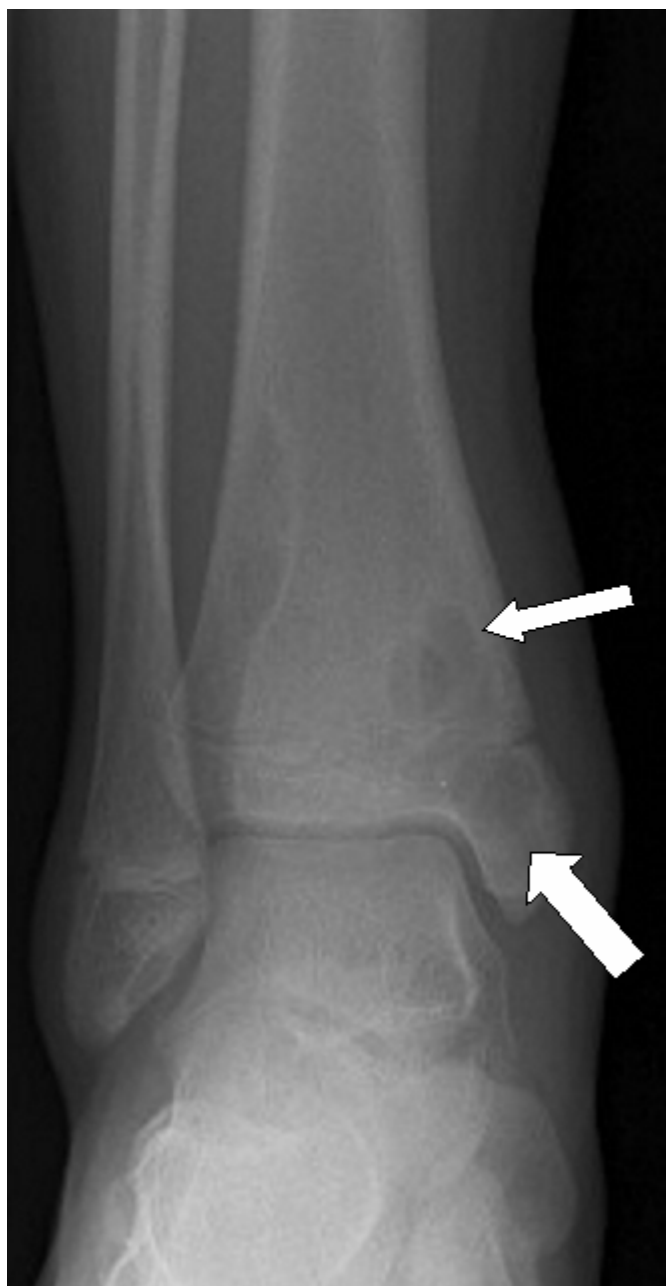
Follow-up AP radiograph of right ankle showing bilocular lytic lesion (narrow arrow) and unilocular lesion in epiphysis (wide arrow).
